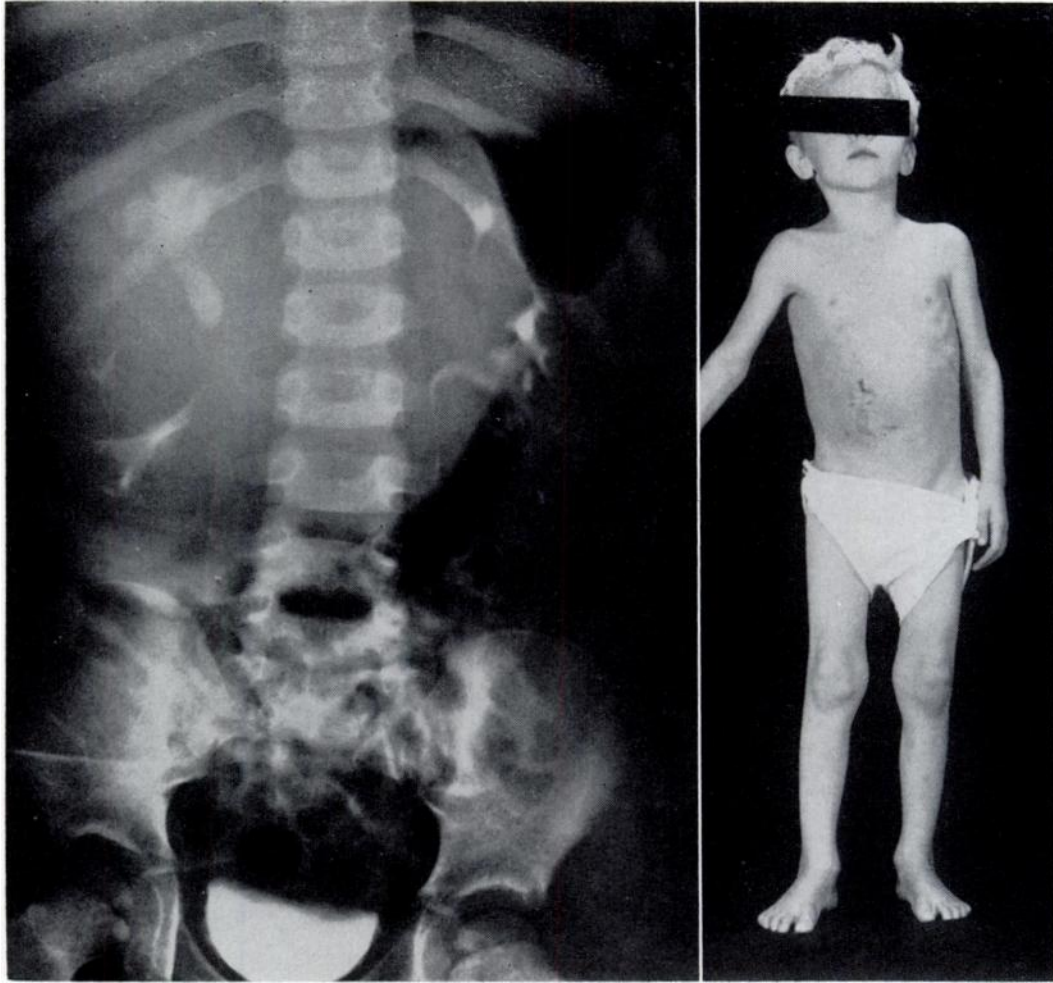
(A, left) Patient T.P., with Wilms' tumor. Intravenous pyelogram shows a soft tissue mass in the right abdomen crossing the midline. The right renal pelvis is distorted. (B, right) Same patient before excision of the tumor. The Wilms' tumor had been "incised and drained." X-ray therapy had decreased the size of the tumor markedly.
